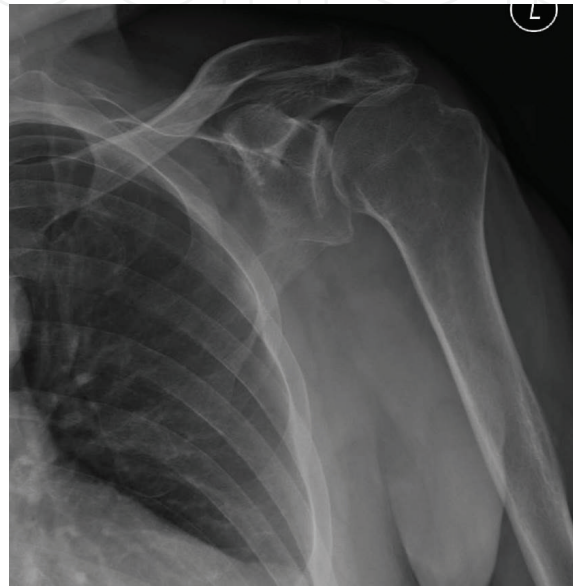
Anterior-posterior plain radiograph of a left shoulder with rotator cuff arthropathy. Note the “high-riding” humeral head, with a decreased acromiohumeral distance, and interrupted Shenton’s line at the inferior aspect of the glenohumeral joint.
